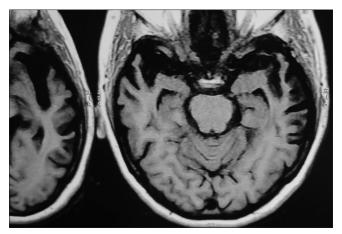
Magnetic resonance imaging of patient 3 showing lateral temporal atrophy
